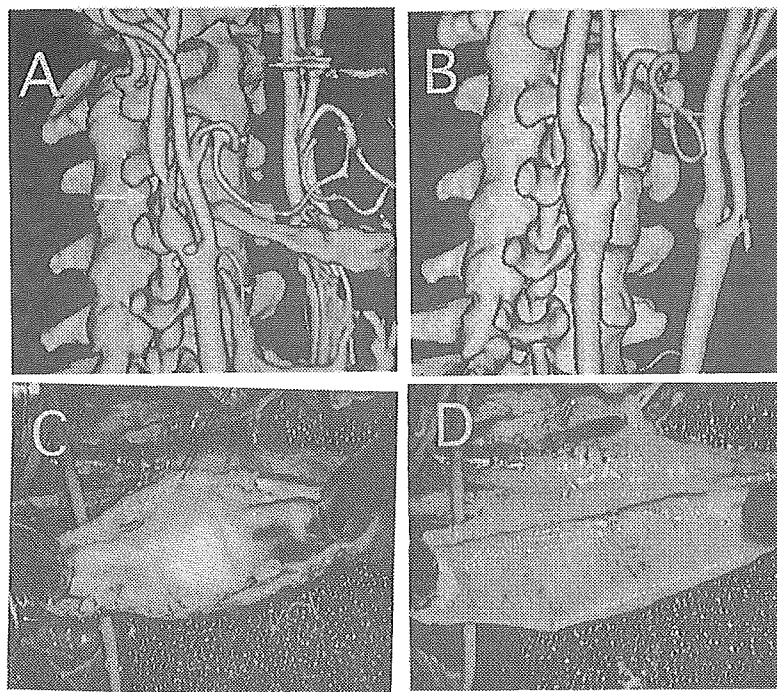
Preoperative 3D-CT angiography demonstrates severe ICA stenosis (A). Postoperative 3D-CT angiography shows complete removal of the stenotic lesion (B). Intraoperative photographs show severe ICA stenosis with atheromatous plaque (C) and complete removal of the lesion (D). 3D-CT: 3 dimensional computed tomography, ICA: internal carotid artery
